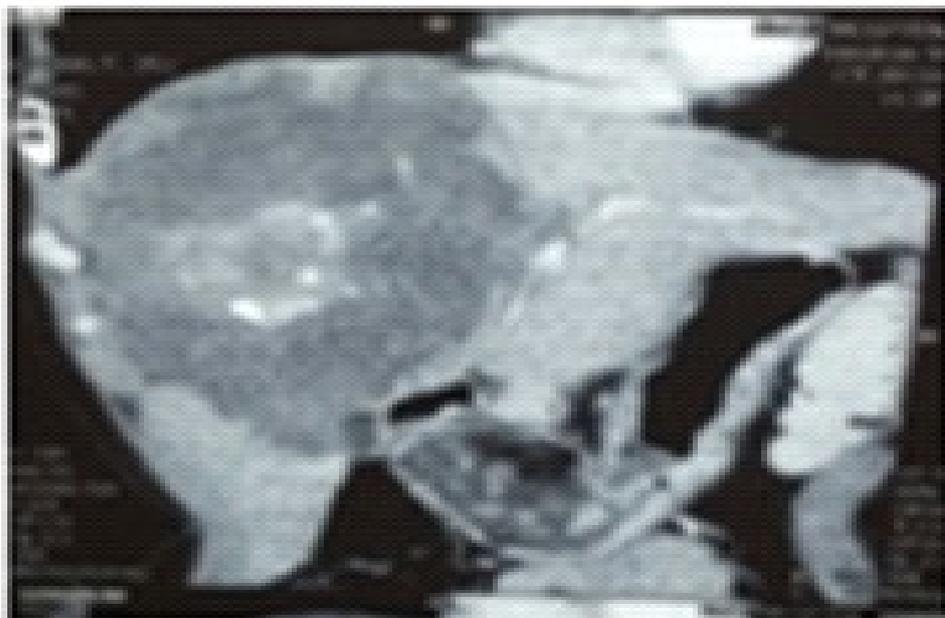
CT scan showing Hypodense lesion with central calcifications
